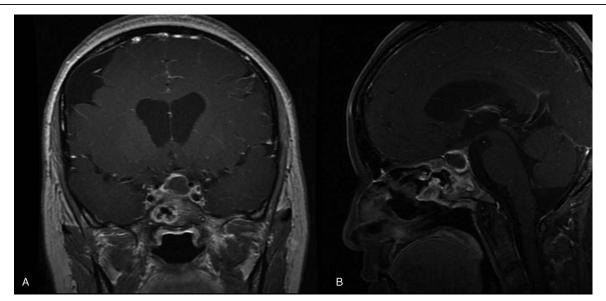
Typical magnetic resonance imaging (MRI) features of secondary pituitary abscess 11 months after the initial transsphenoidal surgery (February 2017). A new emerging mass (size: 15.9 mm × 14.2 mm × 18.0 mm) filled the sella turcica with typical rim enhancement after gadolinium injection in coronal (A) and sagittal (B) views on enhanced MRI.
